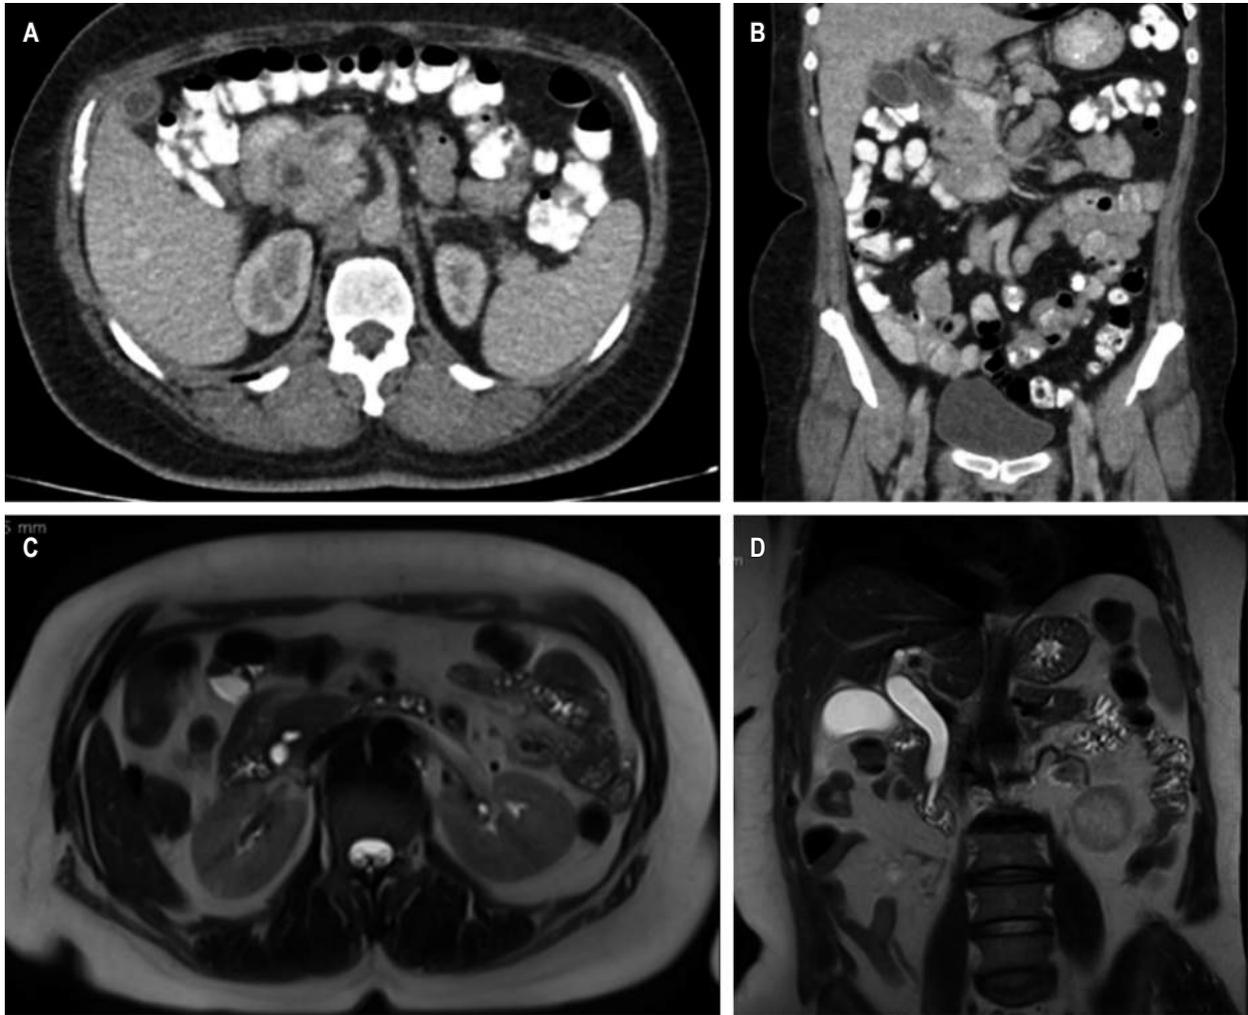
CT scan with evidence of intra- and extrahepatic bile duct dilation (A) axial section (B), and coronal section. Cholangioresonance shows dilation of the bile duct secondary to choledocholithiasis (C) in the axial section and (D) coronal section. Source: Authors' archive.
